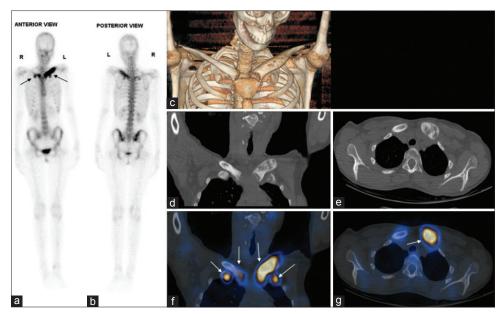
Whole-body bone scan anterior and posterior images (a and b) show increased tracer uptake in bilateral sternoclavicular joints (left >> right), left clavicle, sternum, bilateral first sternocostal joints, and bilateral sacroiliac joints. Computed tomographic three-dimensional reconstruction (c) of the bones of the anterior chest wall shows hyperostosis of the left clavicle. Fused single-photon emission computed tomography-computed tomography coronal and axial images (d-g) show expansile osteolytic, sclerotic destructive lesions in bilateral clavicles and chondral ends of bilateral first ribs (left >> right)
